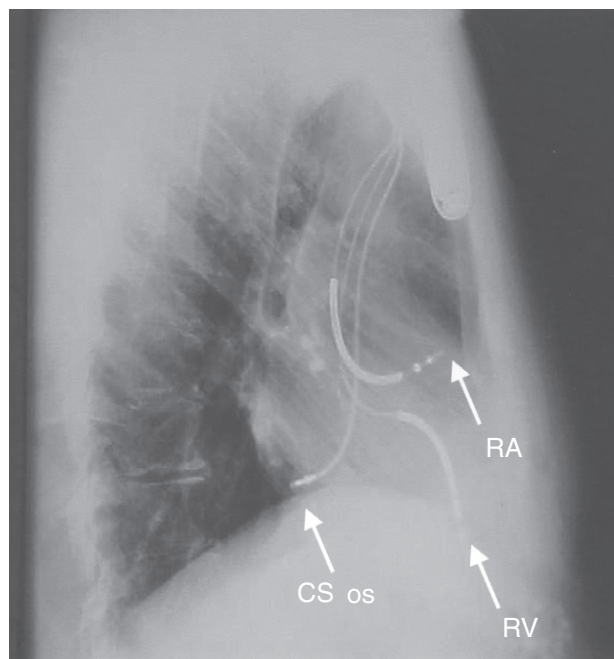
Chest radiograph, lateral view of dual-chamber atrioventricular implantable cardioverter-defibrillator with dual atrial leads. Note the additional atrial pacing lead at the coronary sinus ostium (CS os) to right atrial (RA) and right ventricular (RV) pacing or defibrillation leads.
